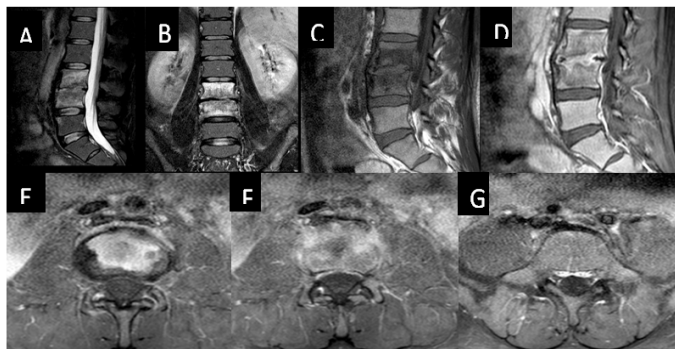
Spine MRI on 21st day depicted a further significant reduction in paravertebral inflammation (F) and dural enhancement (G). Bone marrow edema is also slightly reduced (A, B).
